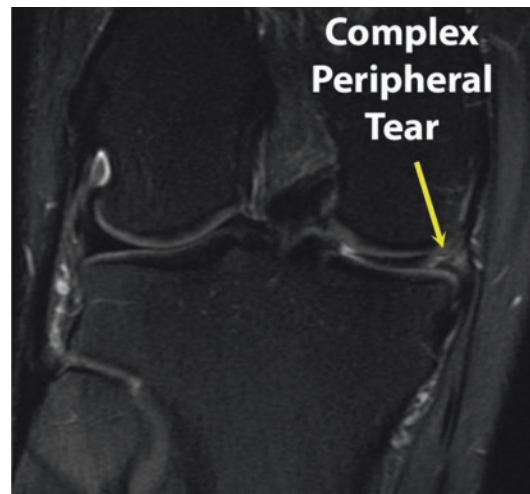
Magnetic resonance image (T2 sequence) demonstrating a complex peripheral tear of a medial meniscus in a right knee
